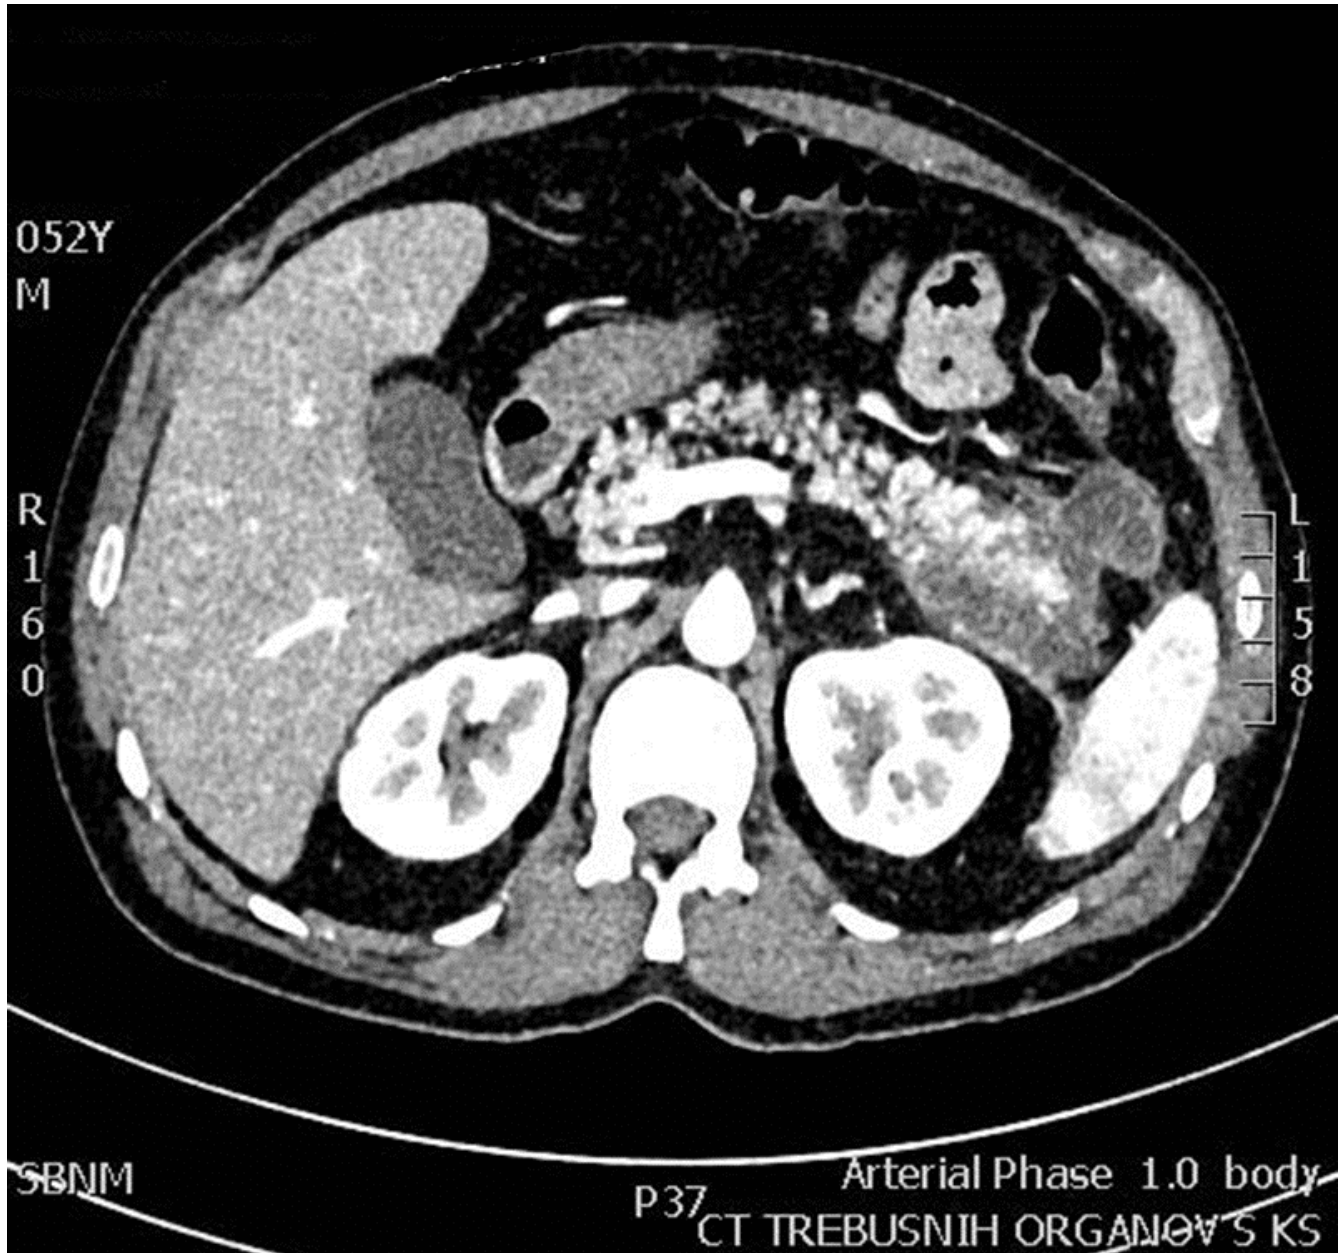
Axial CT scan of the abdomen with IV contrast in the arterial phase shows necrotic pancreatic changes, confirming the diagnosis of acute pancreatitis in a patient with normal lipase levels.
